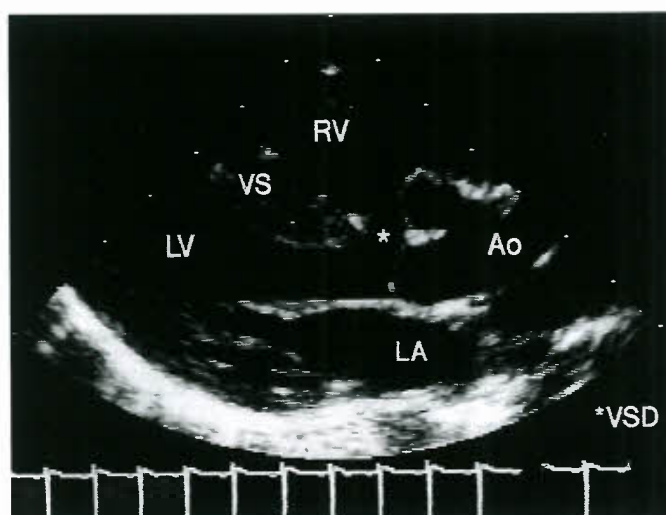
This parasternal long-axis image from a patient with PA-VSD demonstrates a large malalignment VSD (*VSD) and an overriding aortic valve. These features are also present in tetralogy of Fallot and truncus arteriosus. (Ao, aortic root; LA, left atrium; LV, left ventricle; RV, right ventricle; VS, ventricular septum.)
